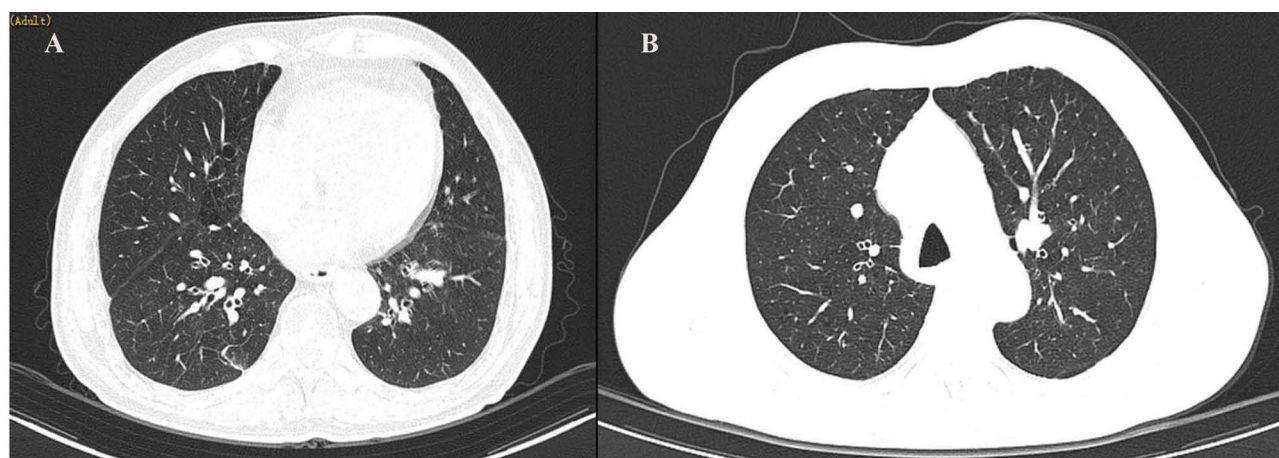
(A) Follow-up chest CT of the patient after 10 months. (B) Follow-up chest CT of the patient after 12 months.
